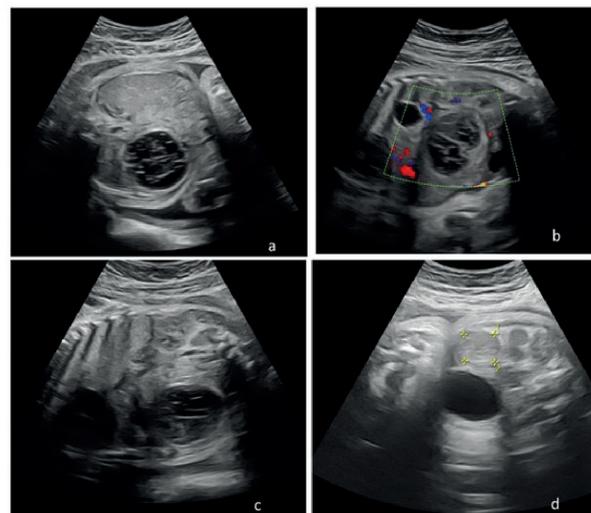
Consecutive prenatal ultrasonography depicting regressing size. (a) at 30 weeks of gestation, 3cm echogenic right sided ovarian tumor, suggesting intracystic hemorrhage, (b) at 32 weeks of gestation, size was increasing , 4.5 cm x 4cm with intracystic hemorrhage, (c) at 34 weeks gestation, the cystic fluid begins to clarify its contents, size wss decreasing, 4.5cm x 3.5cm, (d) at 36 weeks of gestation, size was much decreased, 2.3 cm x 2.3 cm.
